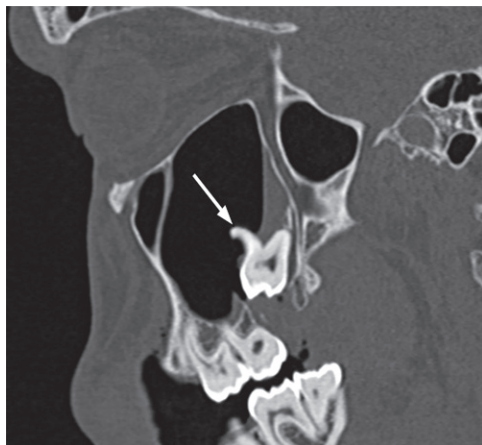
Traumatic tooth displacement. Sagittal nonenhanced CT image (bone window) shows a third molar (arrow) displaced into the maxillary sinus.
